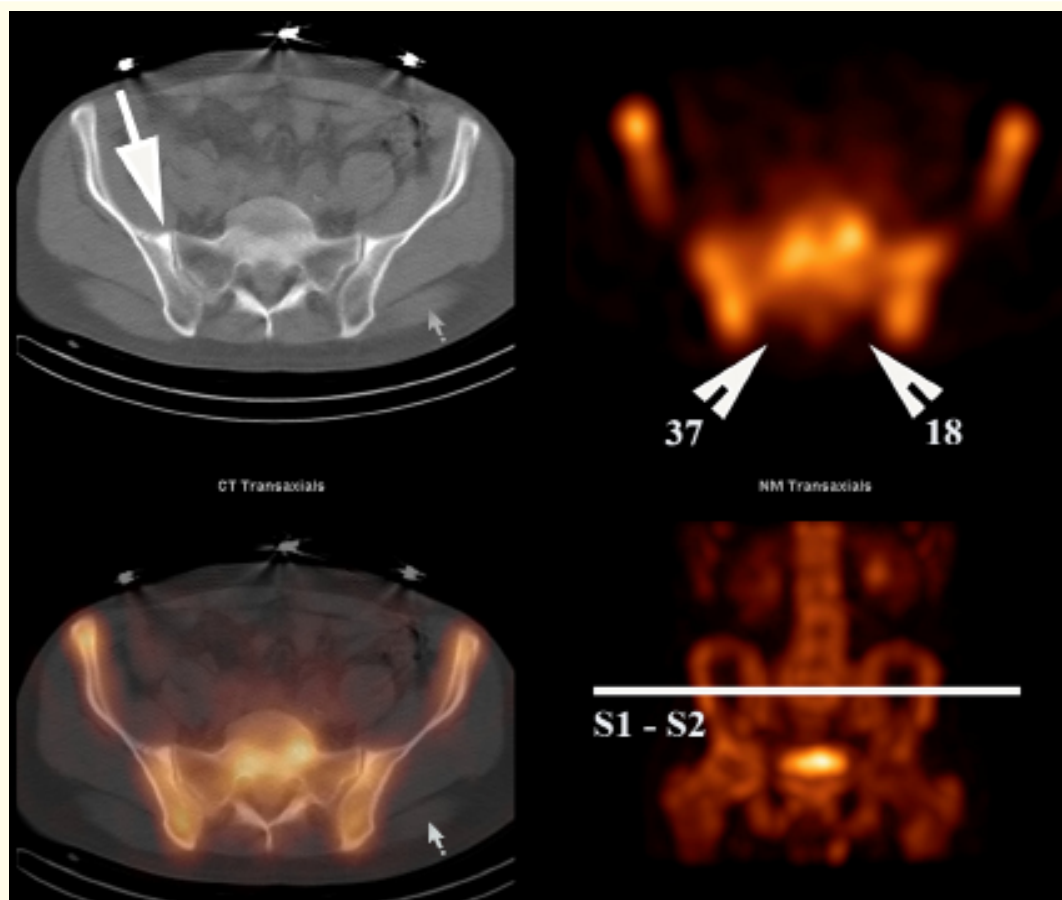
Scintigraphic SPECT/CT study at the S1/S2 level. The arrowheads demonstrate increased uptake in the dorsal interosseous ligament on the right side with the count profile showing an increase in counts on the affected side [37] compared with the uninjured side [18]. Note that the right joint is more sclerotic (arrow).
